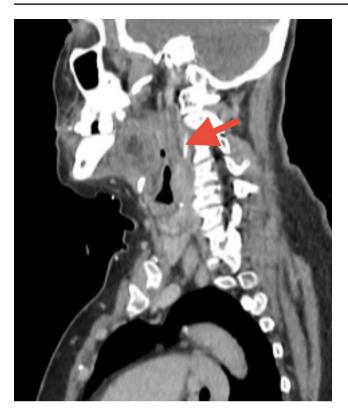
Sagittal image of the CT of the neck showed a fish bone in the prevertebral mucosa space of the oropharynx, at C2/3 level (red arrow)
